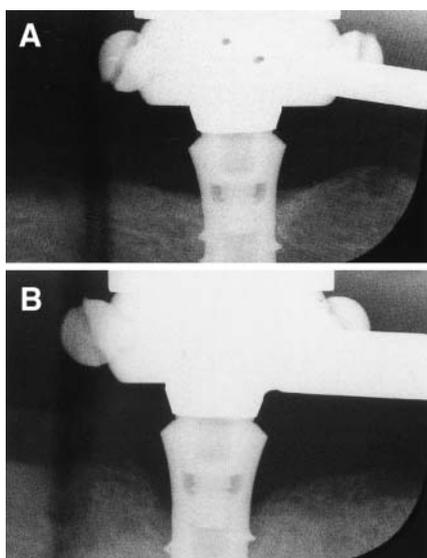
(a) Radiographic view of an ITI implant without bone loss after 1 year. (b) Radiographic view of an ITI implant with bone loss after 1 year.
